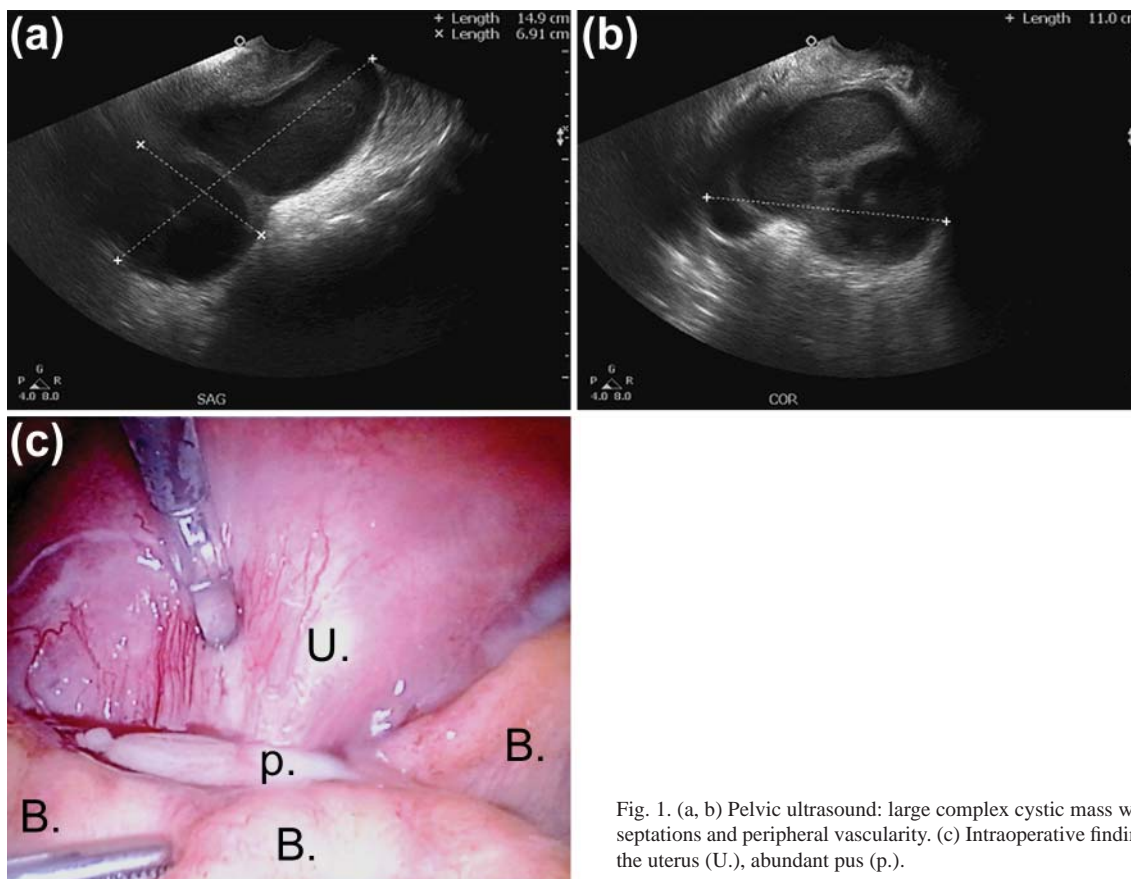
(a, b) Pelvic ultrasound: large complex cystic mass with internal echoes, thick septations and peripheral vascularity. (c) Intraoperative findings: Bowel (B.) encasing the uterus (U.), abundant pus (p.).
